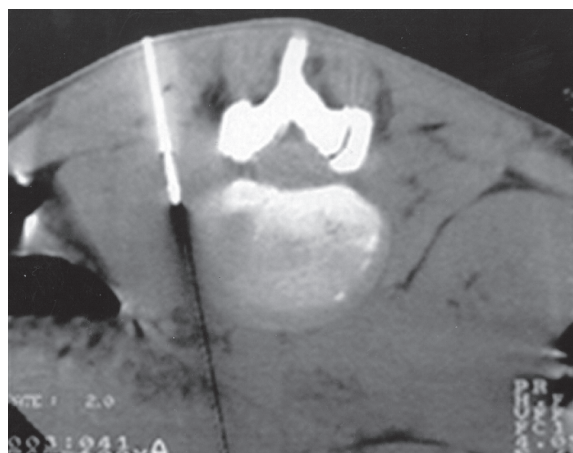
An axial CT scan on prone position shows drainage of the paraspinal abscess by 18-gauge chiba needle.
